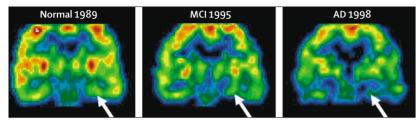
Longitudinal metabolic reductions on FDG-PET
